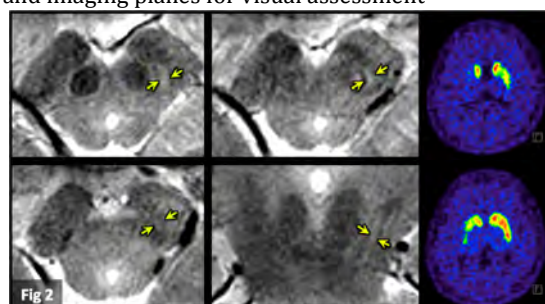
The right nigrosome 1 is affected on MRI, correlating with UPDRS of 7 on the left. PET shows abnormality on the right.
